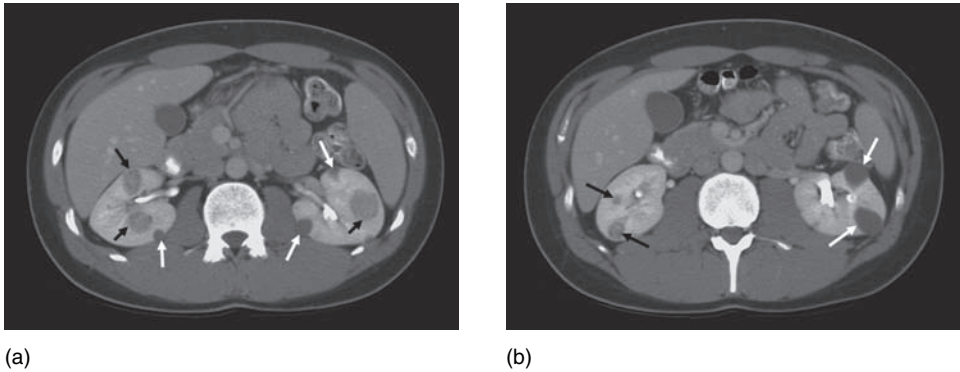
Contrast-enhanced CT Abdomen in a patient with von Hippel–Lindau syndrome (images (a) and (b) taken from the same series). Kidneys show bilateral, multifocal disease, with both cystic (white arrows) and solid lesions (black arrows).
